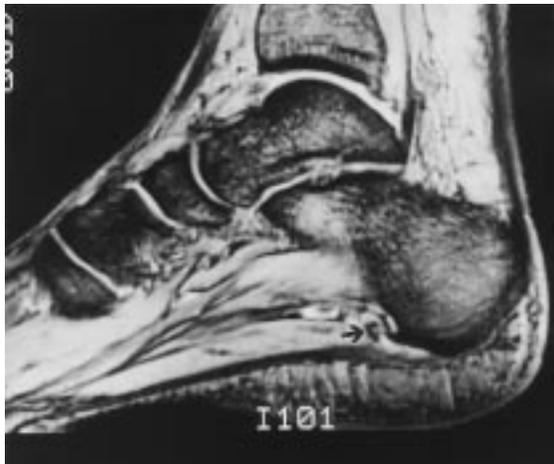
Axial (A) and sagittal (B) T1-weighted magnetic resonance images. Arrows indicate the first branch of the lateral plantar nerve.
